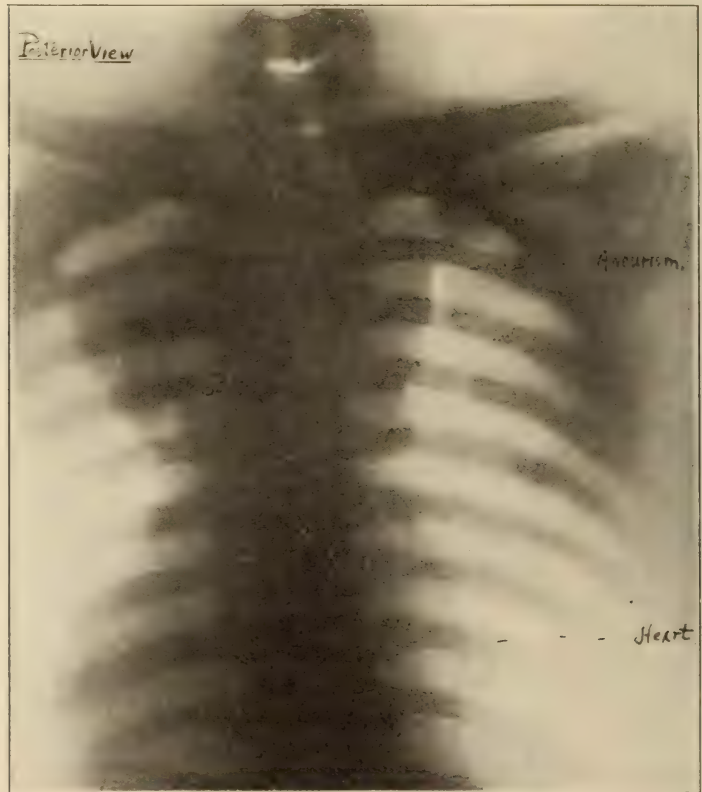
Radiograph Showing Aneurism. Posterior View.
